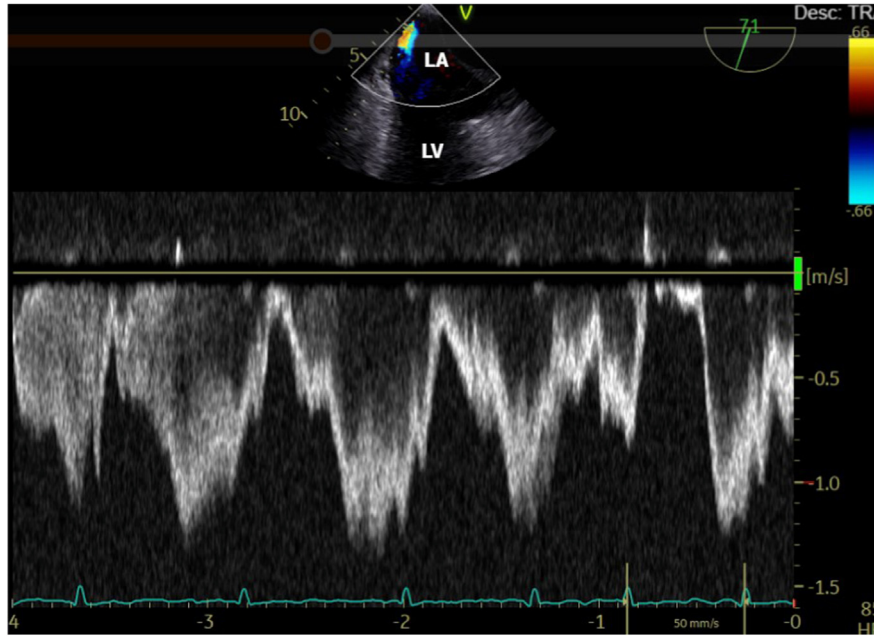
Two-dimensional TEE, midesophageal view, with pulsed-wave Doppler, demonstrates the opening in the CTM.
